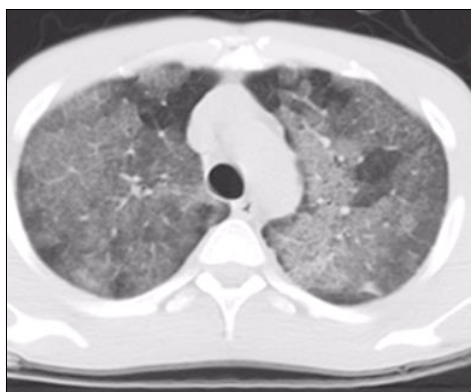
CT scan: “ground-glass” opacities and thickening of the interlobular septa (“crazy-paving” pattern).
